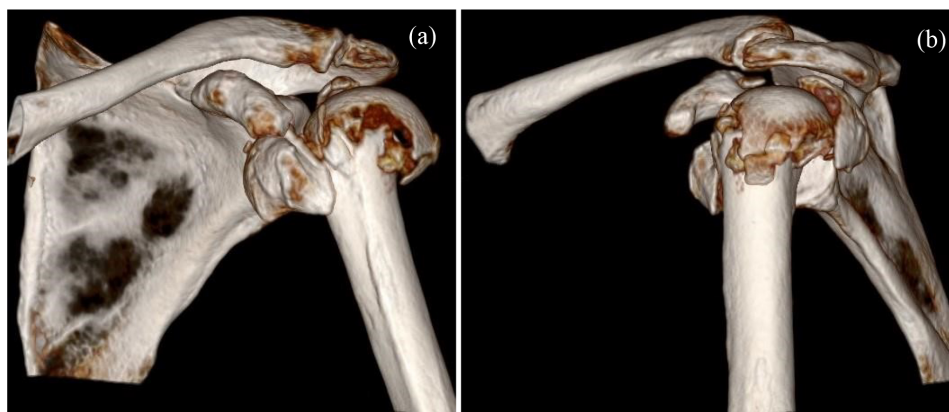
3D CT scan of a displaced 4-part valgus proximal humerus fracture. (a)—coronar view of left shoulder, (b)—sagittal view of left shoulder (same patient as in Fig. 3, right picture, reversed shoulder arthroplasty (RSA)—refer to Fig. 3).
